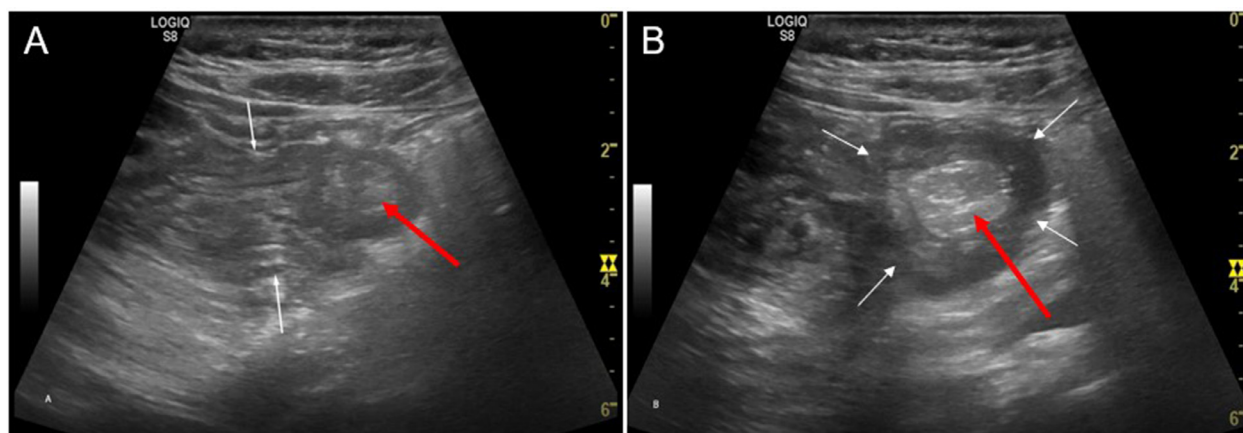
Abdominal ultrasound revealed ascending colocolic intussusception which has a sandwich-shaped appearance on longitudinal views (white arrows in A) and target sign on transverse views (white arrows in B), was adjacent to a hyperechoic mass in the colon lumen (red arrows in A and B).
